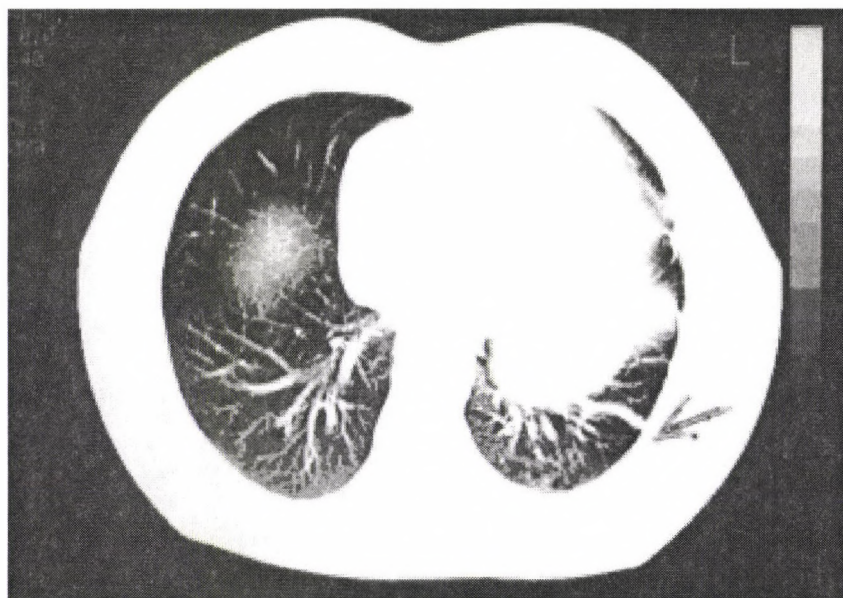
Control thorax CT showing intraparenchymally fibrosis of the tube tract
